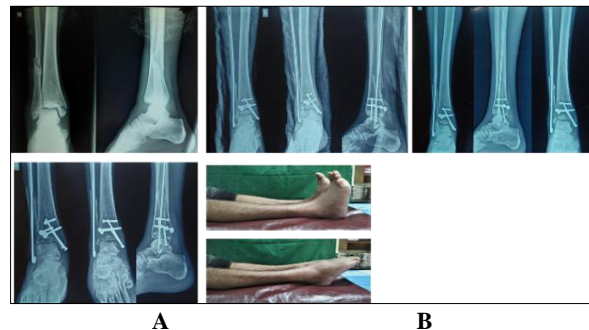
(A) Pre-op, (B) Post-op and follow-up radiographs of 35 year old male
